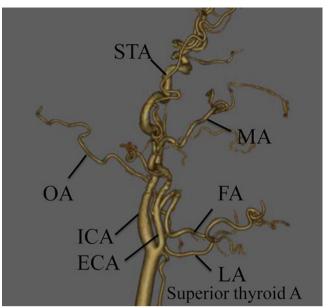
Three-dimensional computed tomography angiography (3D-CTA) of the carotid artery
